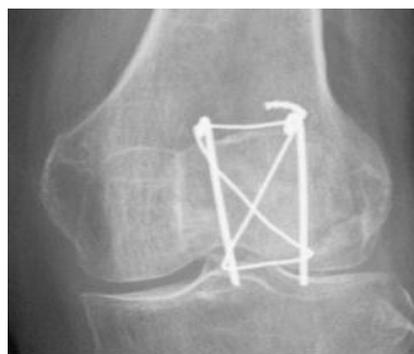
3 months follow up x-rays showing union of patella fixed by modified tension band wiring.
